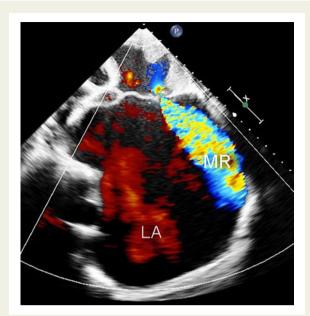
Transthoracic echocardiography apical four-chamber view showing moderate mitral regurgitation. LA, left atrium; MR, mitral regurgitation.
